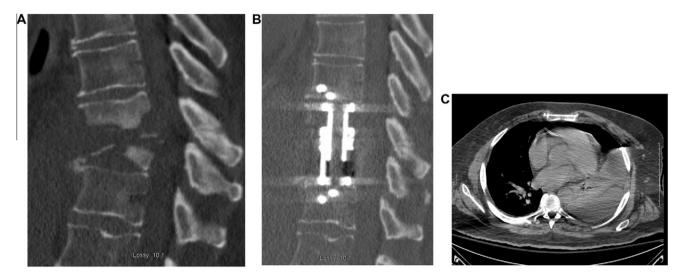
(A) Preoperative sagittal CT scan demonstrating infection and kyphosis at T9–T10; (B) postoperative sagittal CT scan demonstrating good placement of the implant; and (C) axial chest CT scan demonstrating large left-sided hemothorax.
